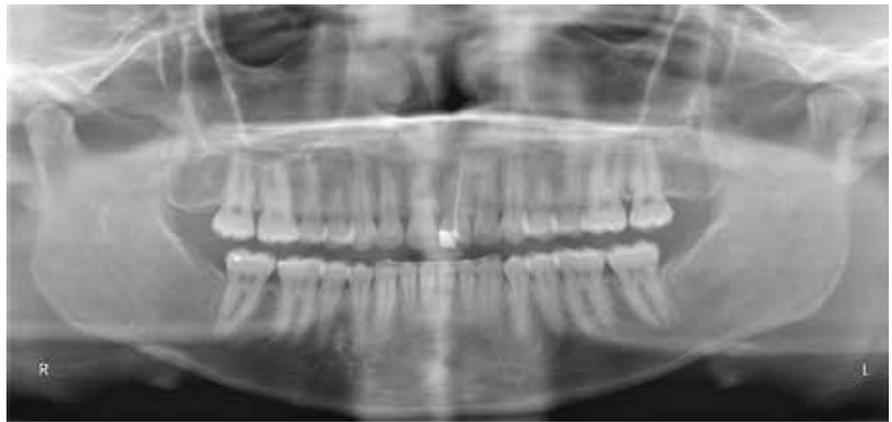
12 months after initial consultation—final panoramic radiograph
